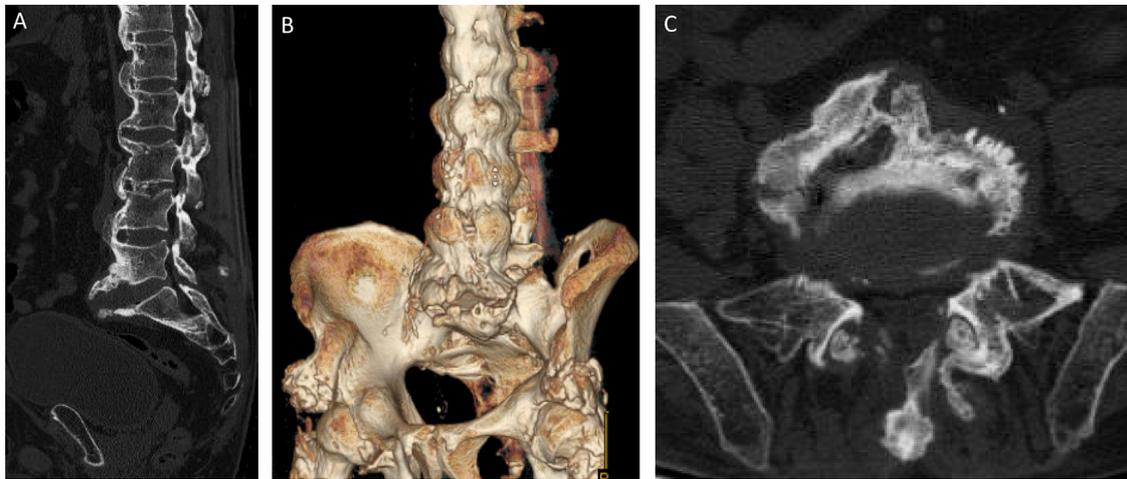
L5-S1 Charcot spine in a C7 tetraplegic patient with DISH (case 1) shown by sagittal CT-scan (A) and 3D spine reconstruction CT-scan (B) with an aspect of hypertrophic pseudarthrosis on 3D reconstruction (B) and axial CT-scan (C).
